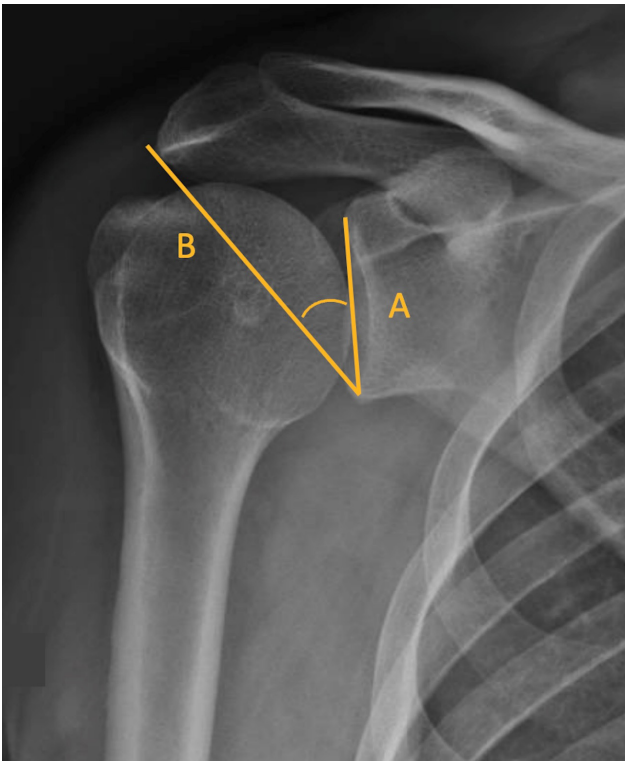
An AP X-ray view of the shoulder depicting the CSA. A: Line from the superior to inferior pole of the glenoid cavity. B: Line from the inferior border of the glenoid to the most infero-lateral border of the acromion.
